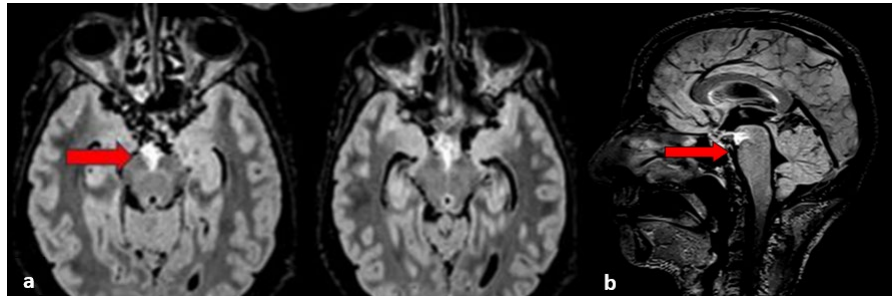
Brain MRI, FLAIR sequence. (a) Axial view and (b) sagittal view showing hyperintensity in the perimesencephalic region, consistent with PAMSH (red arrow).
